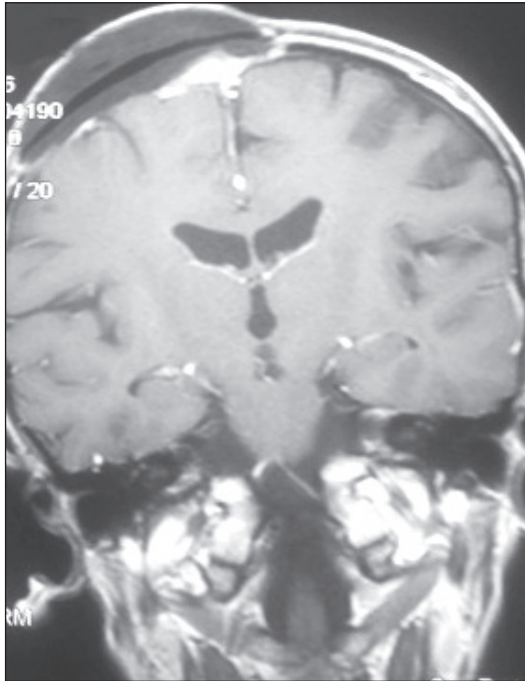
Postoperative month 4. Coronal T1-W MRI from “Case 2” showing that the early postoperative subcutaneous CSF fistula remains.
